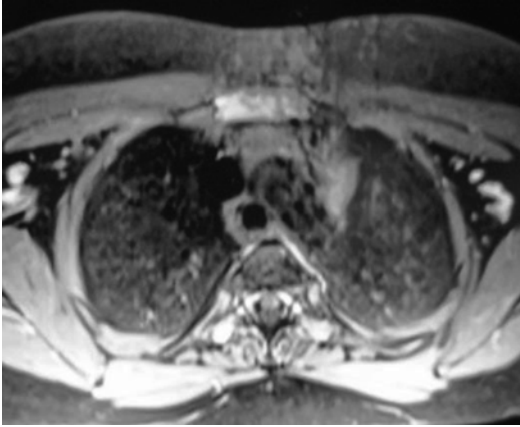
Axial postcontrast MRI of the sternum
